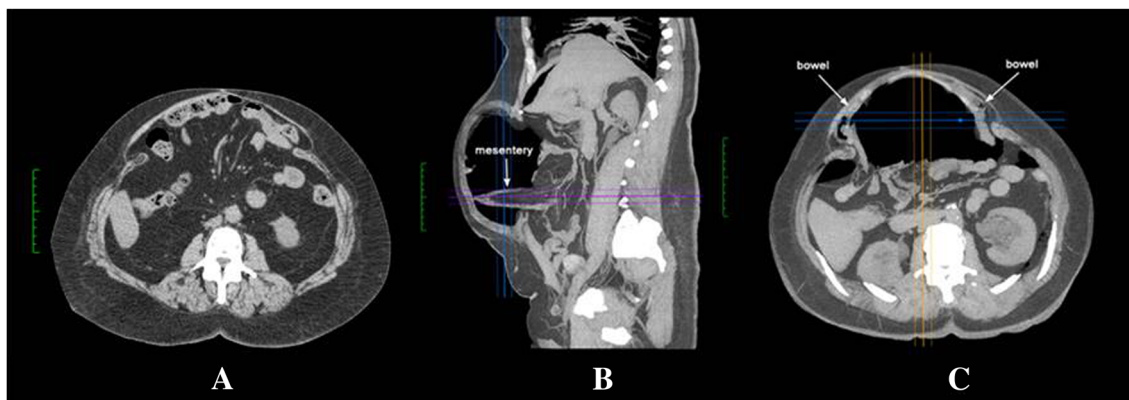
2D axial and Coronal CT images Pre-BTA + PPP and Post-BTA + PPP. 2D CT scan Pre-BTA+PPP (A) and post-BTA and PPP (B, C) showing reduction in hernia contents and pneumatic adhesiolysis of most, but not all visceral adhesions. Surgically important mesenteric adhesions (B) and small bowel adhesions (C) were clearly
